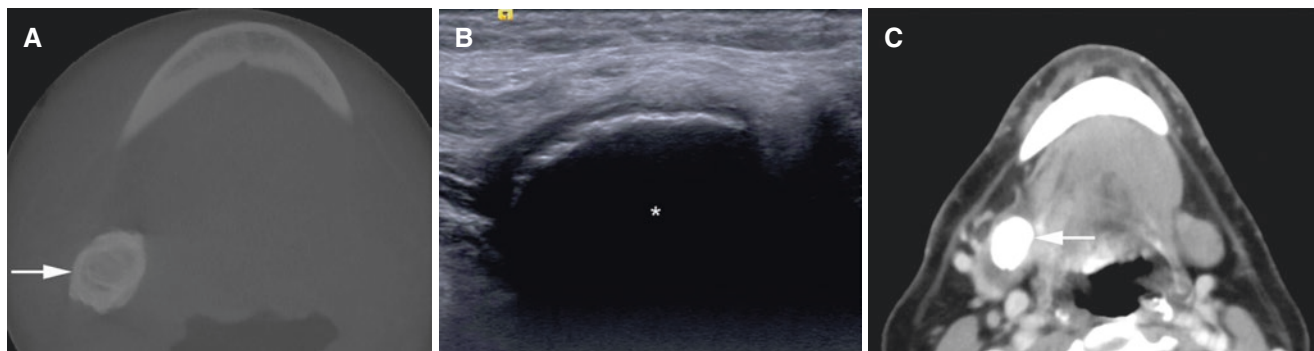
Sialolithiasis, submandibular gland; 69-year-old male with minimal symptoms. (A) Axial CBCT image shows calcified structure (arrow) in submandibular area. (B) Corresponding US image shows total reflection with posterior acoustic shadowing (backshadow) (asterisk)
